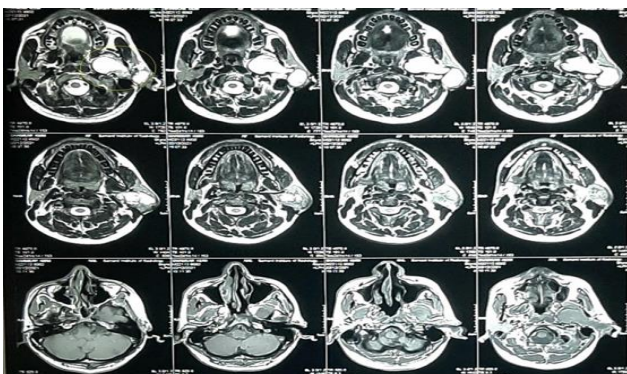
MRI of head and neck showing a swelling in left masticator space extending from foramen ovale.
